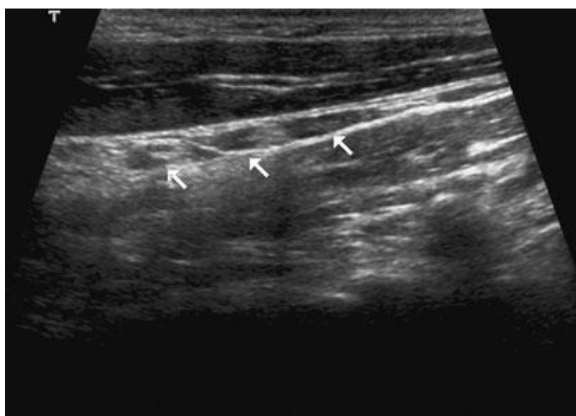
Ultrasonic scanning longitudinal scan of normal jugular lymph nodes (white arrows)
